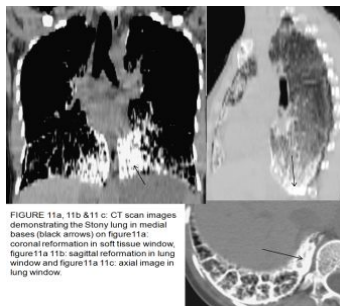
11b & 11c: CT scan images demonstrating the Stony lung in medial bases (black arrows) on figure 11a: coronal reformation in soft tissue window, figure 11a 11b: sagittal reformation in lung window and figure 11a 11c: axial image in lung window.
